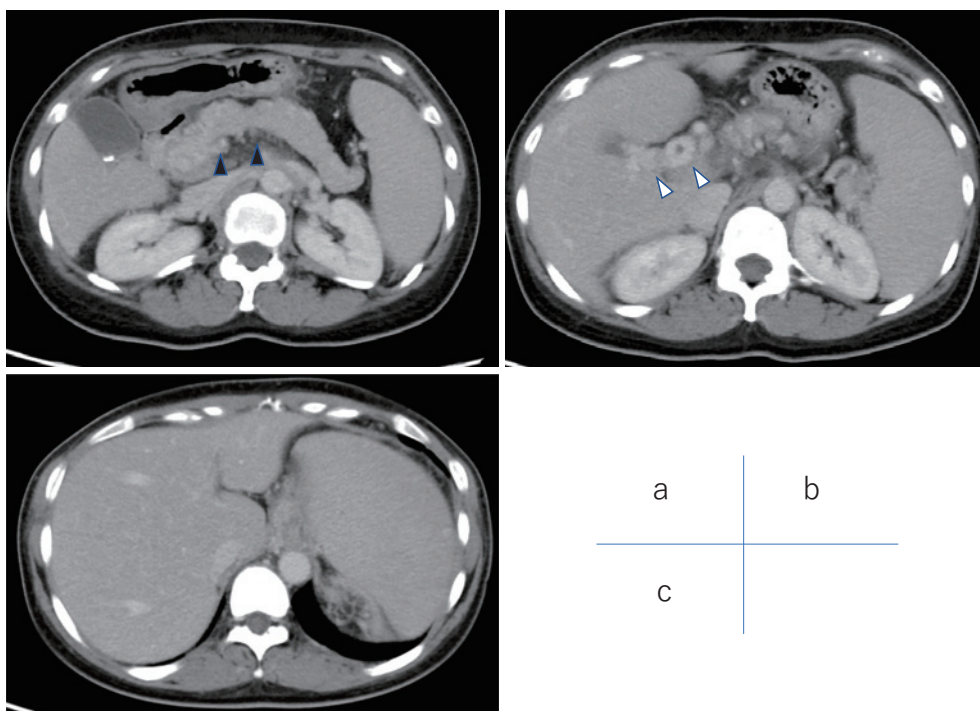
CT revealed portal vein thrombosis extending to the superior mesenteric vein and splenic vein (a black arrow) and cavernous transformation suggesting numerous vascular structures around the portal vein (b white arrow) and no liver cirrhosis (c).
